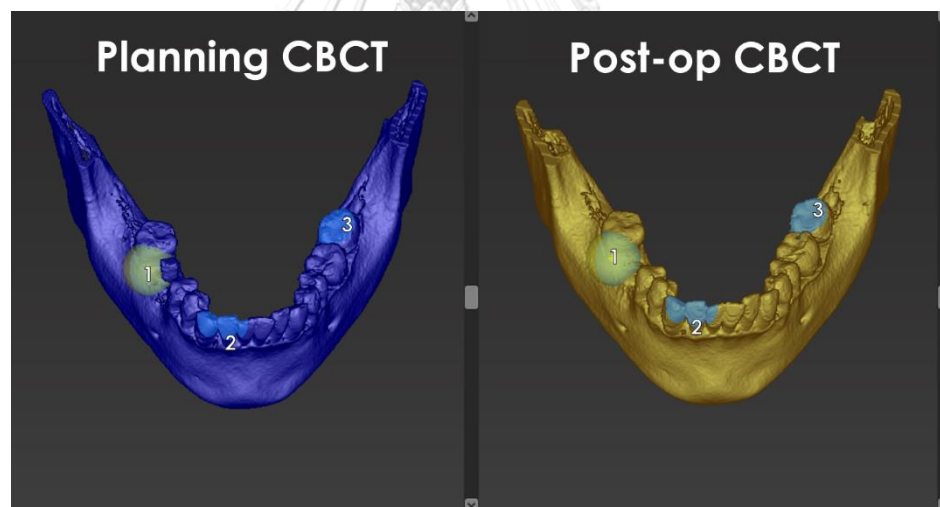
Matching for at least three pairs between virtual planning CBCT and corresponding to post-operative CBCT as landmarks in treatment evaluation tool function in coDiagnostix software
